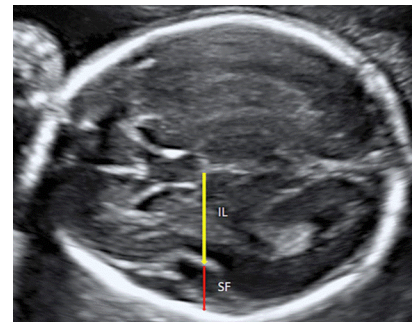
Modified from Authors [10]: demonstrates a standard transthalamic view of the fetal head obtained by transabdominal 2D ultrasound showing the SF and the IL measurements and adjacent anatomical landmarks at 23 weeks of gestation. SF, Sylvian fissure; IL, insular lobe.
